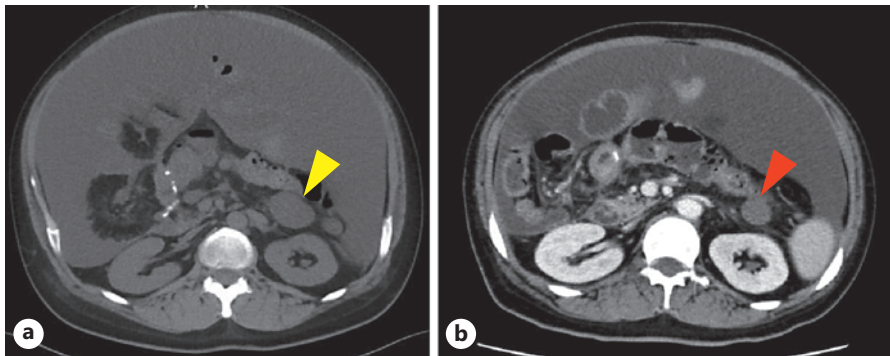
CT findings. a Peritoneal disseminated nodes (yellow arrow) were observed before the start of FOLFOXIRI + BEV therapy. b Their size decreased at the completion of the eighth course (red arrow). A partial response (PR) was achieved according to RECIST.
